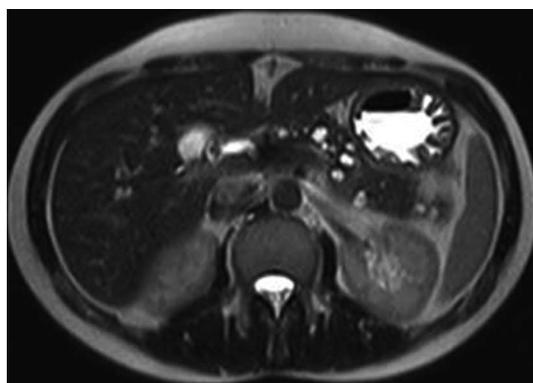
Magnetic resonance imaging. Cyst lesions are bright on T2-weighted images.
